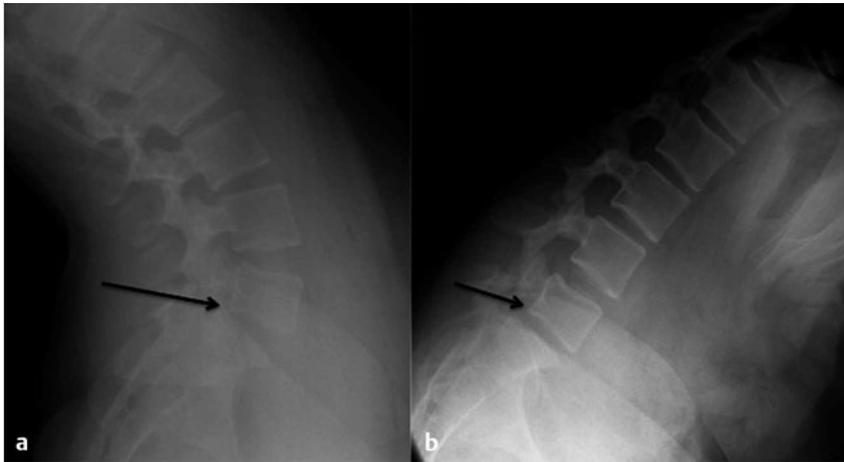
Upright lateral lumbar radiographs showing increased movement of the vertebral bodies with (a,b) extension and flexion. The black arrows highlight the grade 1 spondylolisthesis at L5-S1.
